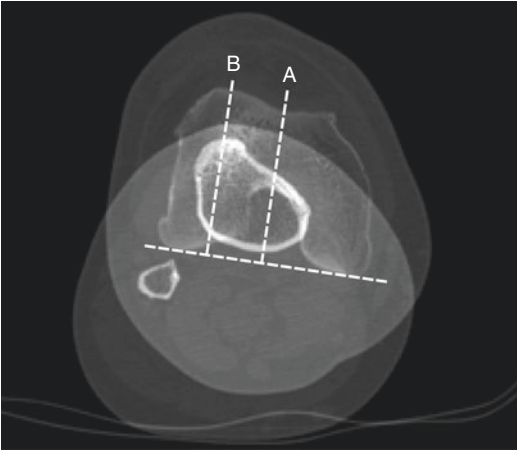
The tibial tuberosity–trochlear groove (TT-TG) distance is measured using two superimposed CT slices: the first (A) through the most proximal part of the trochlear groove, where the notch looks like a Roman arch, and the other (B) through the most proximal part of the tibial tuberosity. The two reference points are projected perpendicularly to the bicondylar line. The distance between their projections is the TT-TG value
